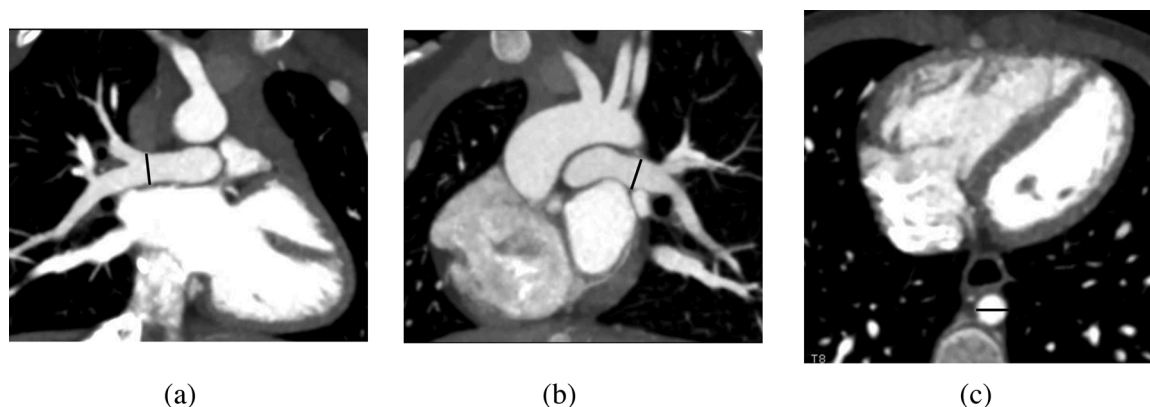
CTA in the right and left oblique views (a-b) and in axial view (c) demonstrating the positions where the right (a) and left (b) pulmonary arteries, and aorta (c) were measured for calculation of the McGoon ratio.
